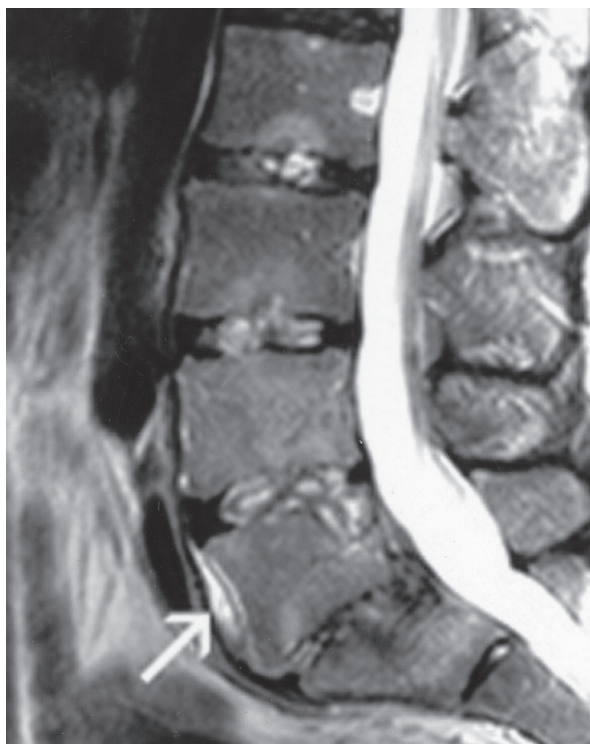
Intravenous contrast enhanced T1-weighted and T2-weighted MR images show a small amount of the paravertebral fluid (arrows) with prominently resolved intensity of spondylitis according to the preoperative MR imaging. There is also a decrease size of the epidural abscess.
